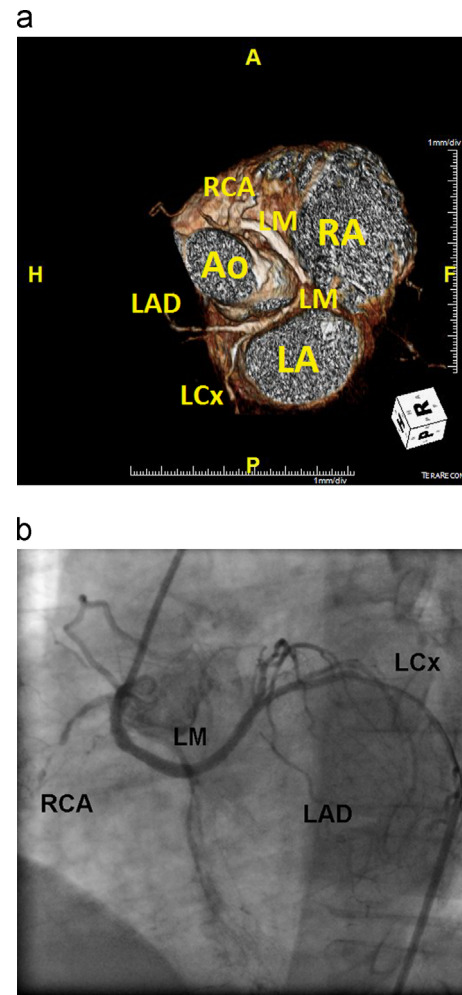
The left main coronary artery (LM) arising from the right coronary sinus with interarterial course. a – MS-CT volume-rendered 3-D image; b – selective coronary angiography: right anterior oblique 15° caudal 15° view.
